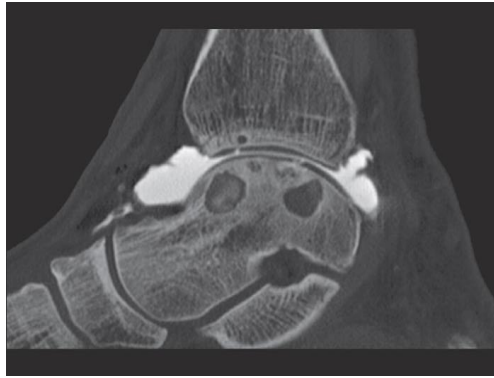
Lesions of the talus in CT-Scan
